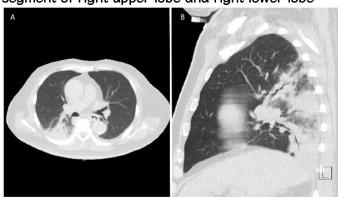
Chest computed tomography. Axial CT scan (A) and sagittal reconstruction (B) showed multifocal consolidation with air-bronchogram at posterior segment of right upper lobe and right lower lobe
